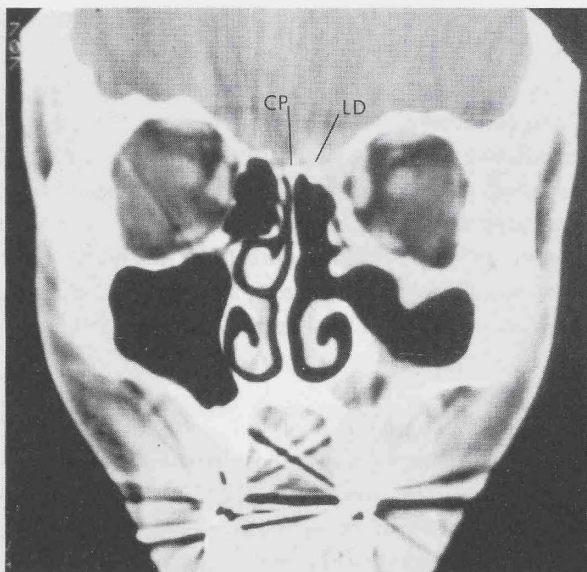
Coronal CT-scan following endoscopic sinus surgery revealing the site of a CSF leak, the cribriform plate (CP), and the lamina dura (LD).
